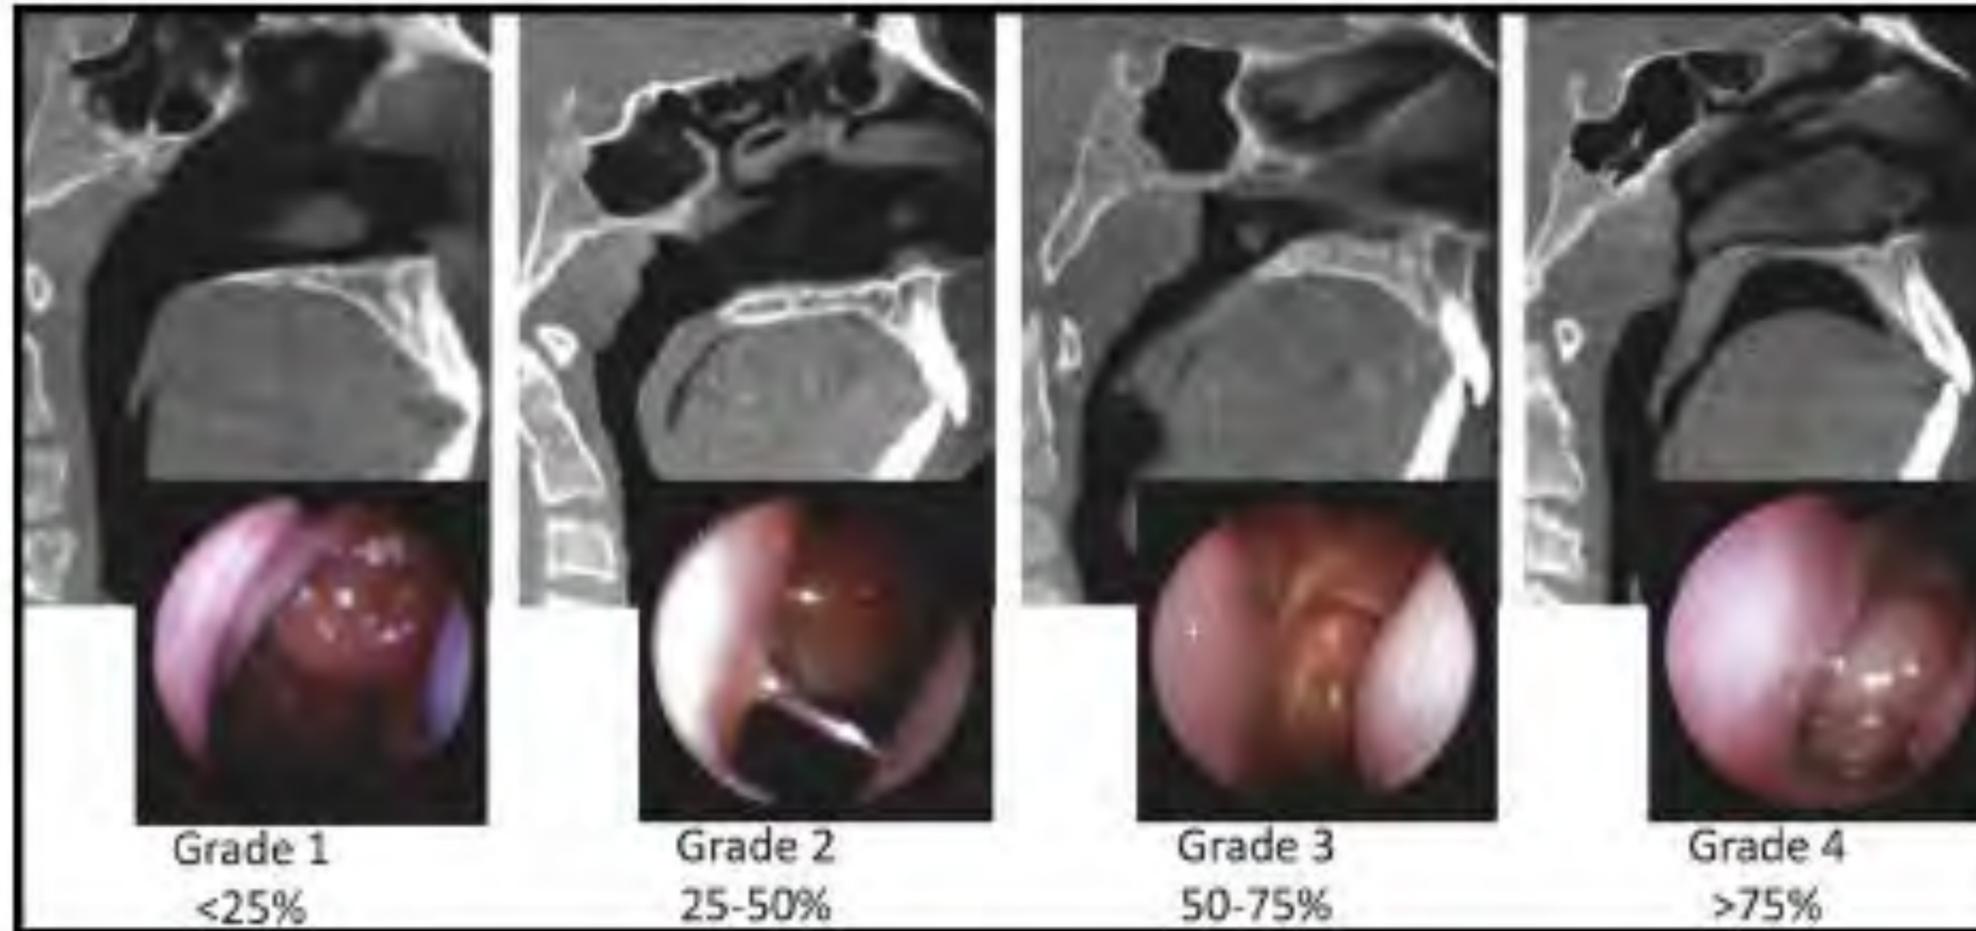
Adenoid size in CBCT midsagittal slice and corresponding adenoid viewed with NE.
